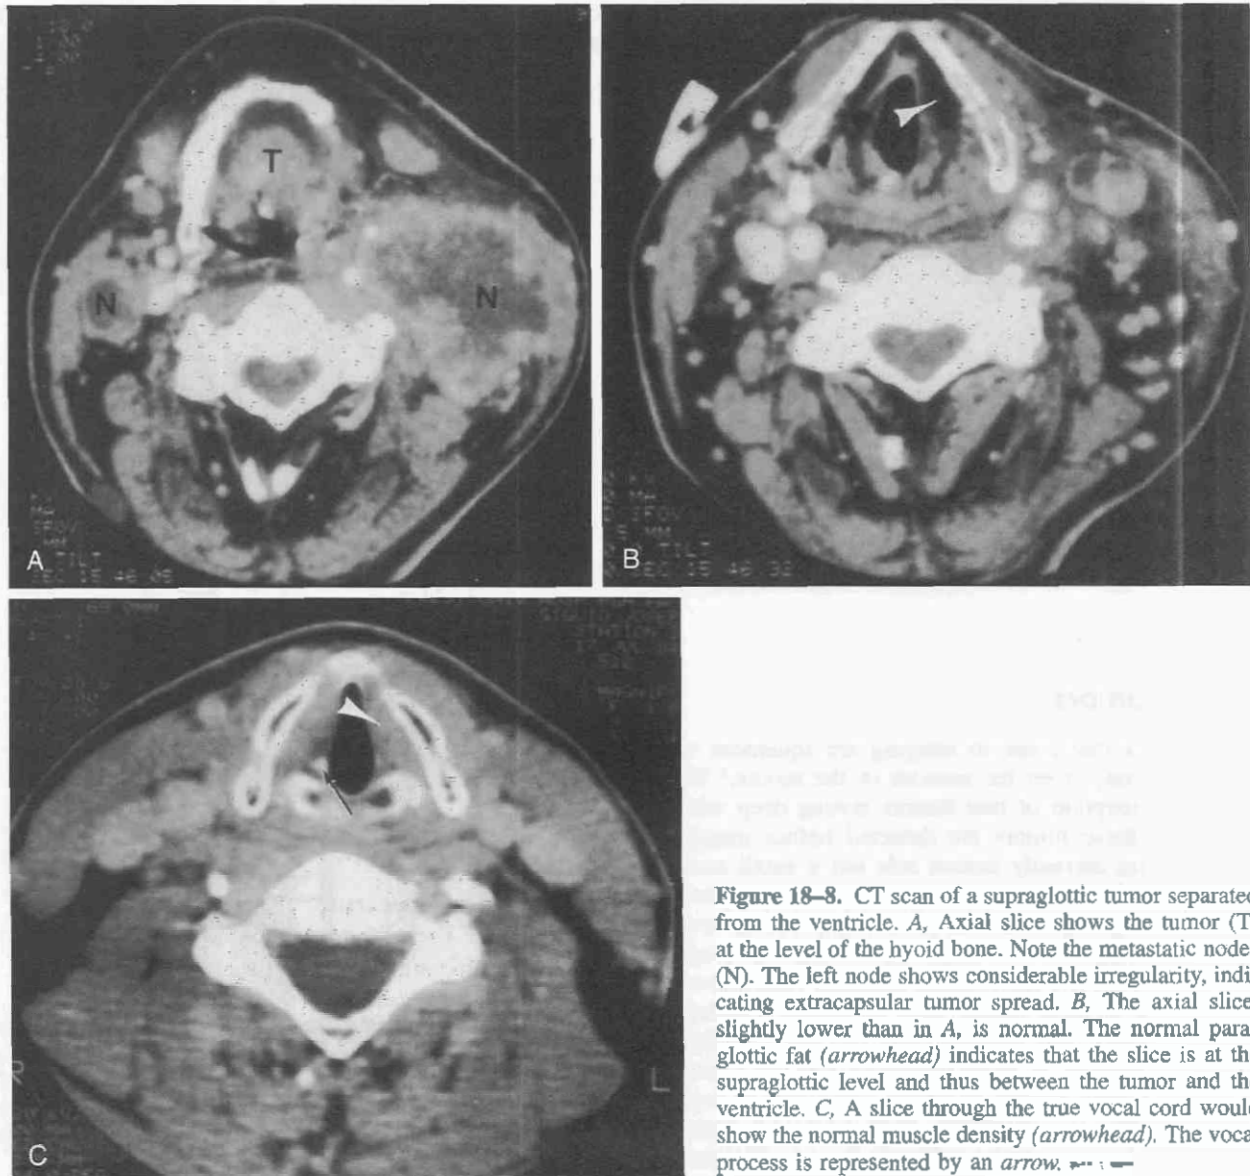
CT scan of a supraglottic tumor separated from the ventricle. A, Axial slice shows the tumor (T) at the level of the hyoid bone. Note the metastatic nodes (N). The left node shows considerable irregularity, indicating extracapsular tumor spread. B, The axial slice, slightly lower than in A, is normal. The normal paraglottic fat (arrowhead) indicates that the slice is at the supraglottic level and thus between the tumor and the ventricle. C, A slice through the true vocal cord would show the normal muscle density (arrowhead). The vocal process is represented by an arrow.
